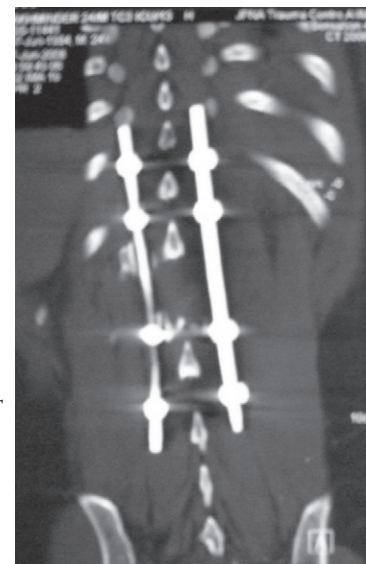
Post operative CT scan of the same patient showing transpedicular rod and screw fixation
